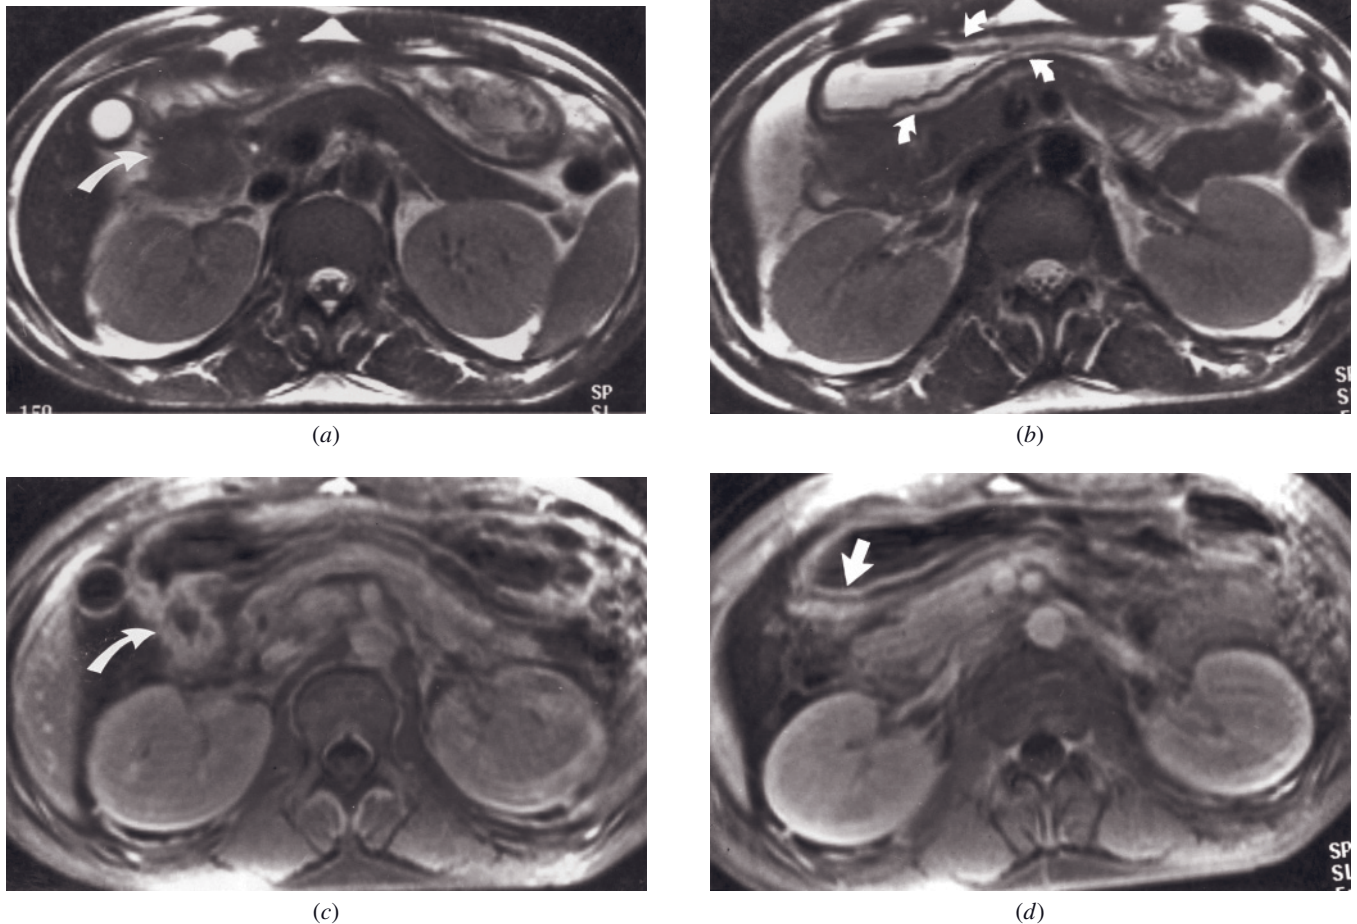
Duodenal Crohn disease and gastric outlet obstruction. Transverse T2-weighted SS-ETSE (*a, b*) and 2-min postgadolinium fat-suppressed (*c, d*) images. The stomach and proximal duodenum are dilated *a* with transition point in the second portion of the duodenum. The duodenum at the level of obstruction shows increased wall thickness on the T2-weighted image (curved arrow, *a*). High signal intensity of the submucosa of the antrum and first portion of the duodenum is identified (curved arrows, *b*). The thickened portion of the duodenum demonstrates moderately increased mural enhancement (curved arrow, *c*), with mucosa and serosa layers of the antrum and proximal duodenum demonstrating moderate enhancement reflecting moderate chronic inflammatory changes (arrow, *d*). Low signal intensity of the submucosa on the postgadolinium T1-weighted images (*c, d*) represents submucosal edema and corresponds to high signal intensity on the T2-weighted image. (Reprinted with permission from Marcos HB, Semelka RC: Evaluation of Crohn's disease using half-Fourier RARE and gadolinium-enhanced SGE sequences: initial results. *Magn Reson Imaging* 18: 263–268, 2000.)
